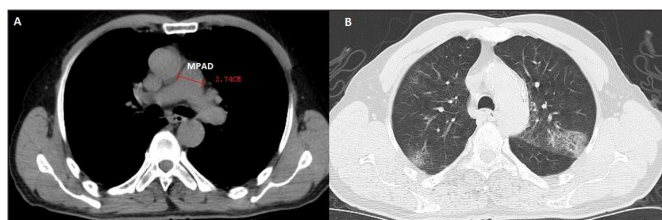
Axial noncontrast thoracic computed tomography images of a 63-year-old male patient A) Measurement of the main pulmonary artery diameter (27 mm) B) Peripheral ground-glass areas due to COVID-19 involvement in the upper lobes of both lungs at the time of initial admission
